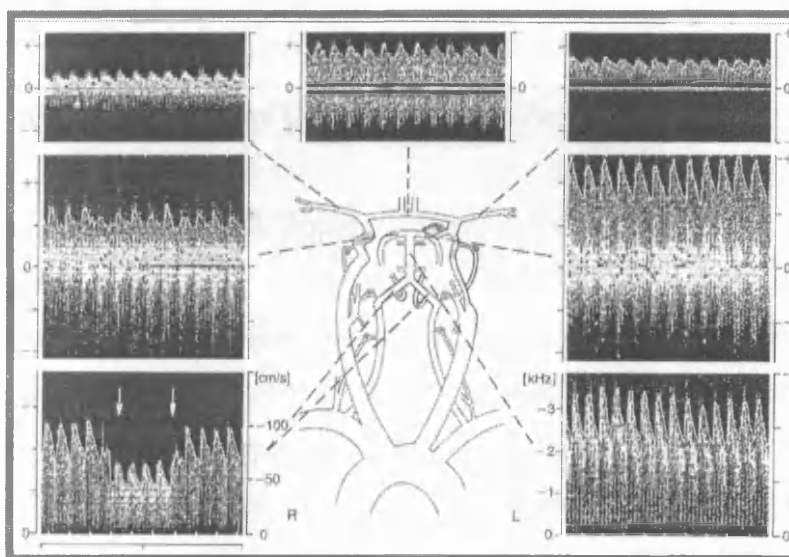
Transcranial Doppler ultrasound (TCD) measures mainly mean arterial blood flow velocities in the distal internal carotid/proximal middle cerebral artery (the main site of the large-blood vessel disease). From von Reuter and von Budingen, 1993.
